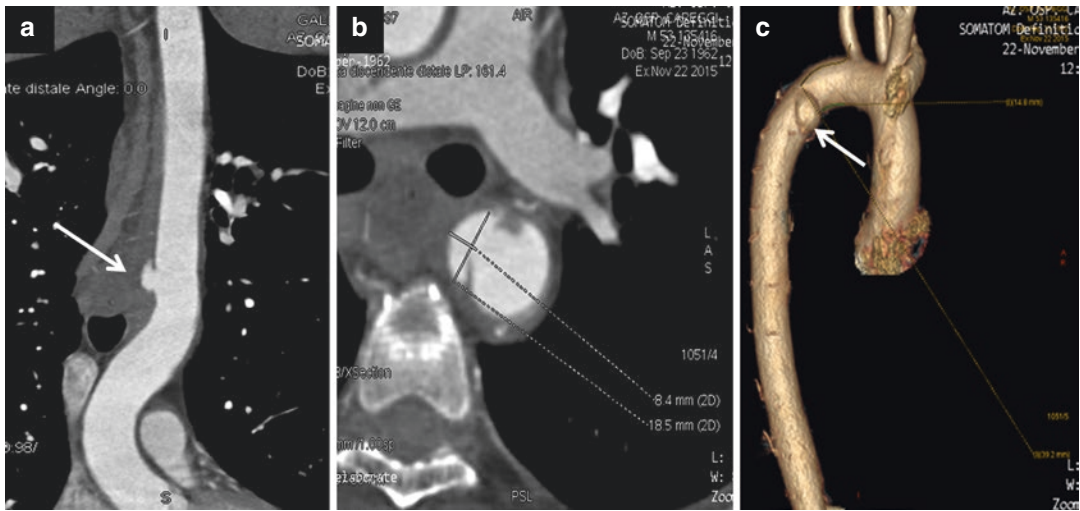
Aortic isthmus, same large post-traumatic pseudoaneurysm (white arrows). (a) Reformatted linear image; (b) axial CT scan; (c) reformatted 3D image
